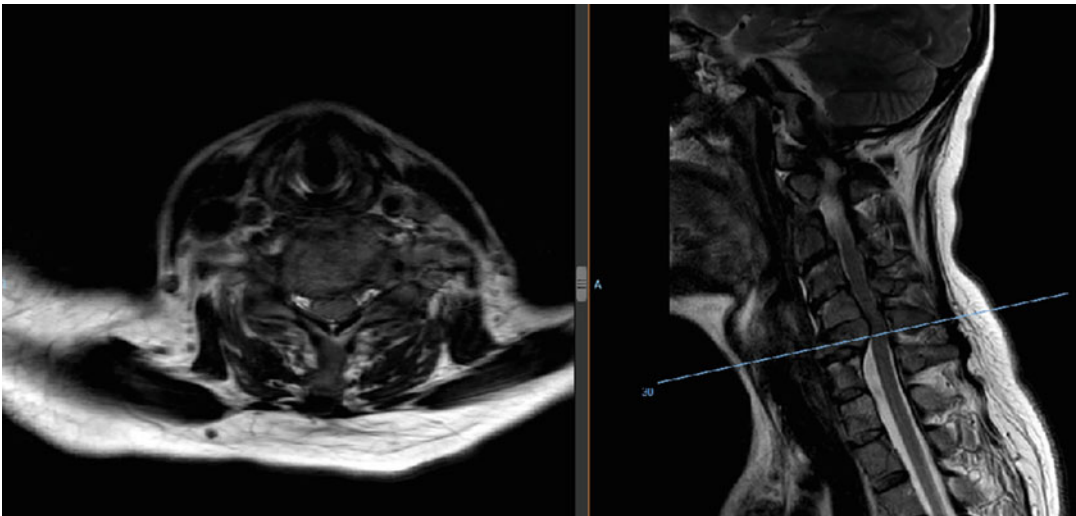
A 50-year-old female with metastatic breast cancer to the bone only presented with neck pain/tenderness, increased upper limb reflexes, and urinary incontinence. Tenderness over the T5 level with associated bilateral radiating pain was also noted. An axial T2-weighted MR image (on left) through the C6 vertebra and a sagittal T2-weighted MR image of the cervical spine and upper
